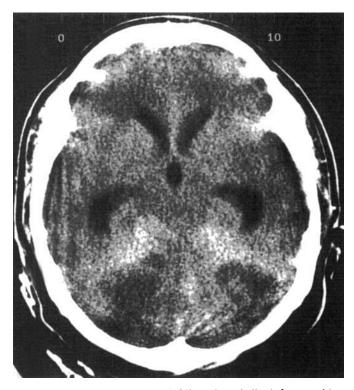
Head CT scan with bilateral cerebellar infarcts and hydrocephalus.
